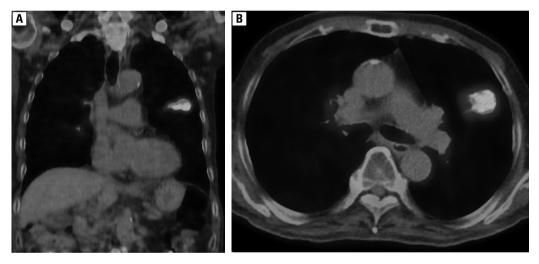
Positron emission tomography/computed tomography (PET/CT) showed 18F-fluorodeoxy glucose (FDG) uptake in the mass (standardized uptake value max: 26.3)
